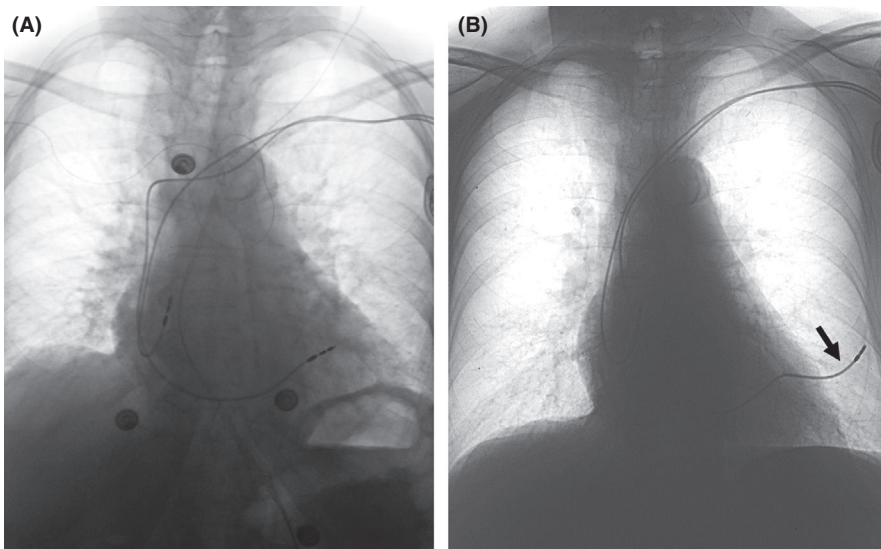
A-B, Chest X-rays performed 1 day (A) and 60 days (B) after pacemaker implantation. The day after the procedure, both atrial and ventricular pacemaker leads were properly positioned at the right atrial appendage and septal mid-wall, respectively (A). B, shows the same postero-anterior view of the patient's heart 60 days after the procedure: while the atrial lead is located at the same place as compared with (A), the ventricular lead is well beyond the left cardiac margin and clearly migrated in the left hemithorax (arrow)
